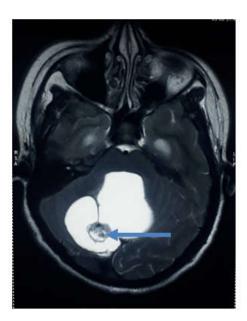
Axial T2 MRI image showing hyperintense lesion in posterior fossa with heterogenous intensity mural nodule (arrow)
